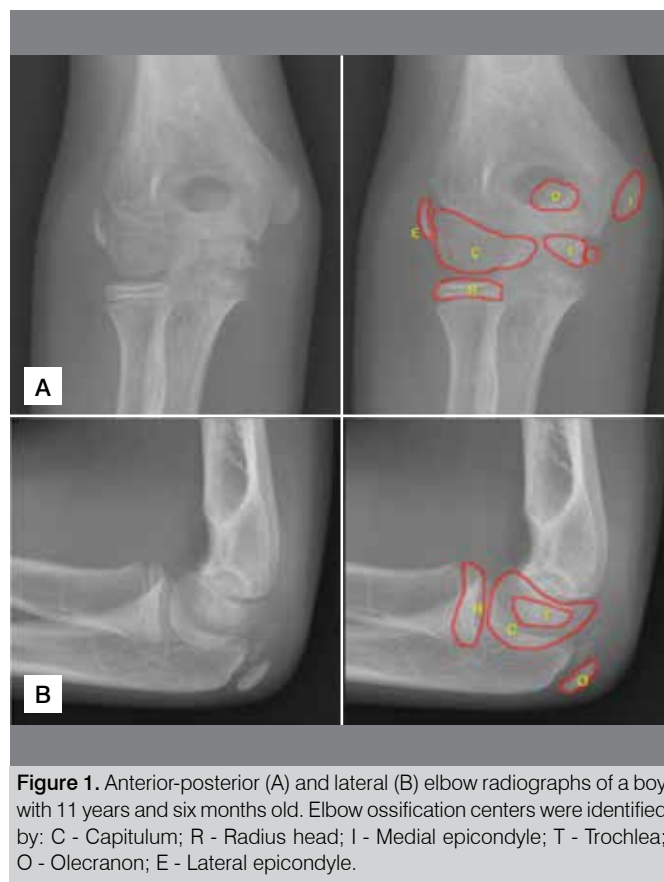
Anterior-posterior (A) and lateral (B) elbow radiographs of a boy with 11 years and six months old. Elbow ossification centers were identified by: C - Capitulum; R - Radius head; I - Medial epicondyle; T - Trochlea; O - Olecranon; E - Lateral epicondyle.
